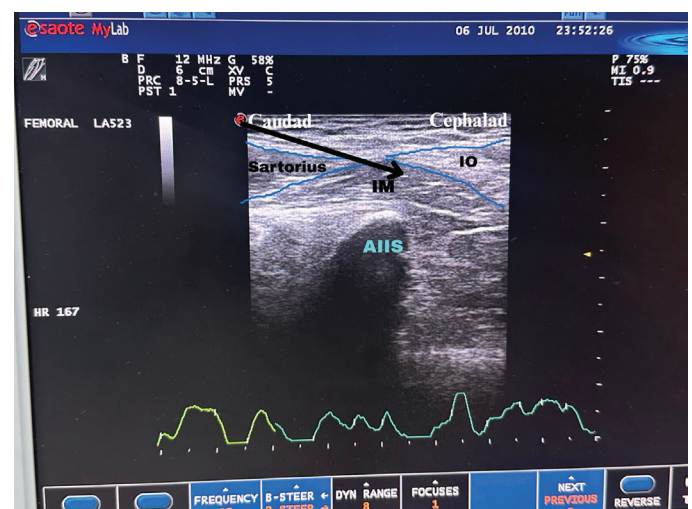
Ultrasound image of suprainguinal fascia iliaca block
